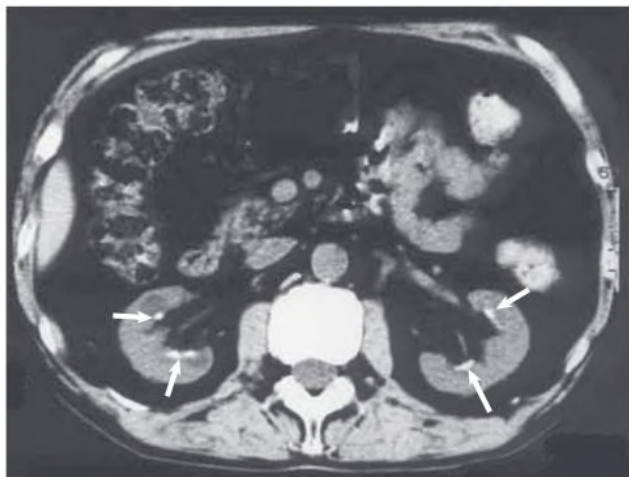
Papillary Calcifications in Analgesic Nephropathy. Non-contrast-enhanced computed tomography scan of a patient with long-time analgesic abuse shows thinning of the renal parenchyma and typical papillary calcifications (arrows). (Courtesy Dr. Yoshifumi Ubara, Toranomon Hospital, Tokyo.)
